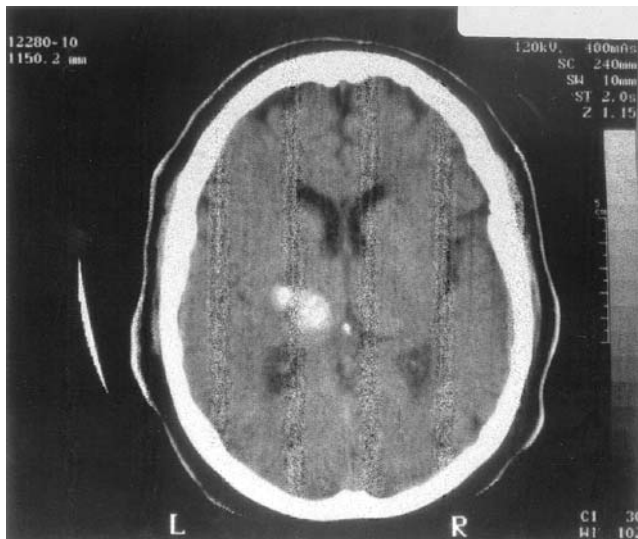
CT scan showing the left thalamic lesion of the patient here reported, performed 50 days after insult. Left side of the brain shown on left side of the figure
